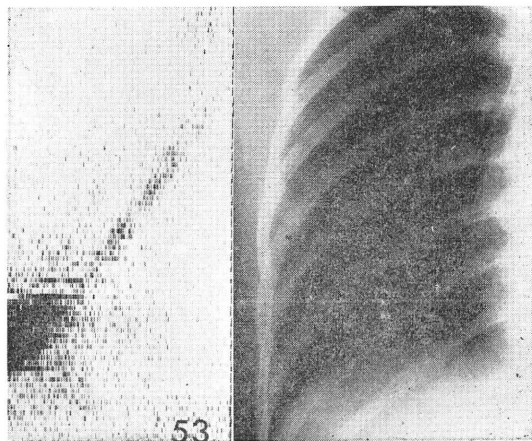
Scan of the distribution of aggregated albumin (AA) particles, 53 minutes after their injection into the lung through a catheter extending into the right main bronchus. On the right the catheter can be seen in the X-ray of the chest.
